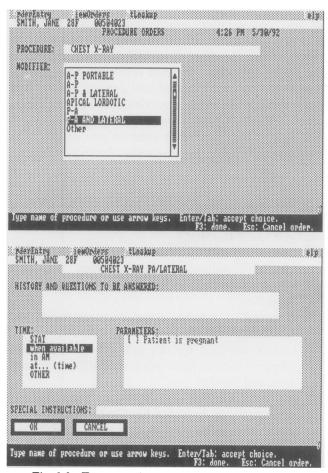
Two steps in the ordering of a chest x-ray.
